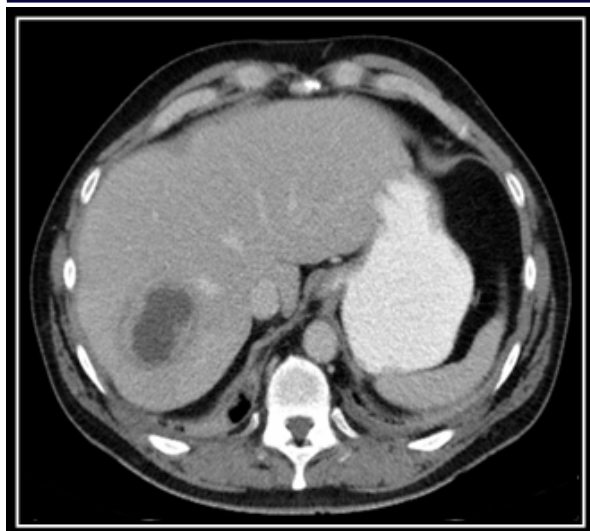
Axial Section Of CT Showing Well Defined Hypodense Lesion In The Segment VII Of Liver With Peripheral Rim Enhancement In Portal Venous Phase.
